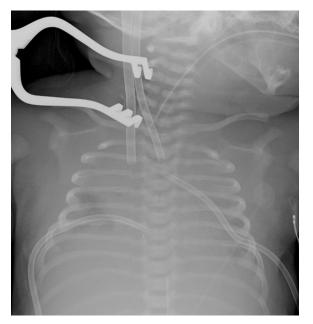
A chest radiograph taken immediately after cannula placement appears to show the arterial and venous cannula tips projecting over the region of the proximal SVC and aortic arch. Flows could not be achieved during initiation of ECMO, because of pump stoppage when 60 mL/kg/min of flow was reached.
